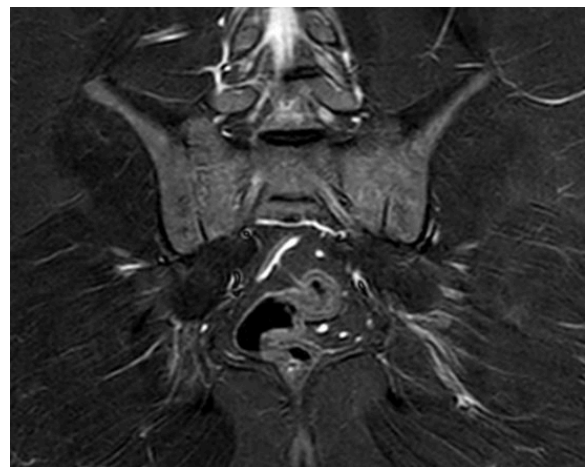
MRI showing ankylosed Sacroiliac joints
